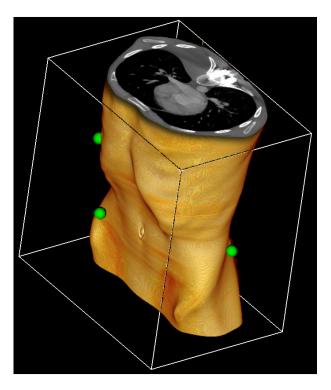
Newer CT scanners can collect information on the whole volume being studied. This dataset, rendered with OsiriX, can be manipulated in many different ways to obtain images that highlight the part of the body that we need to study.
